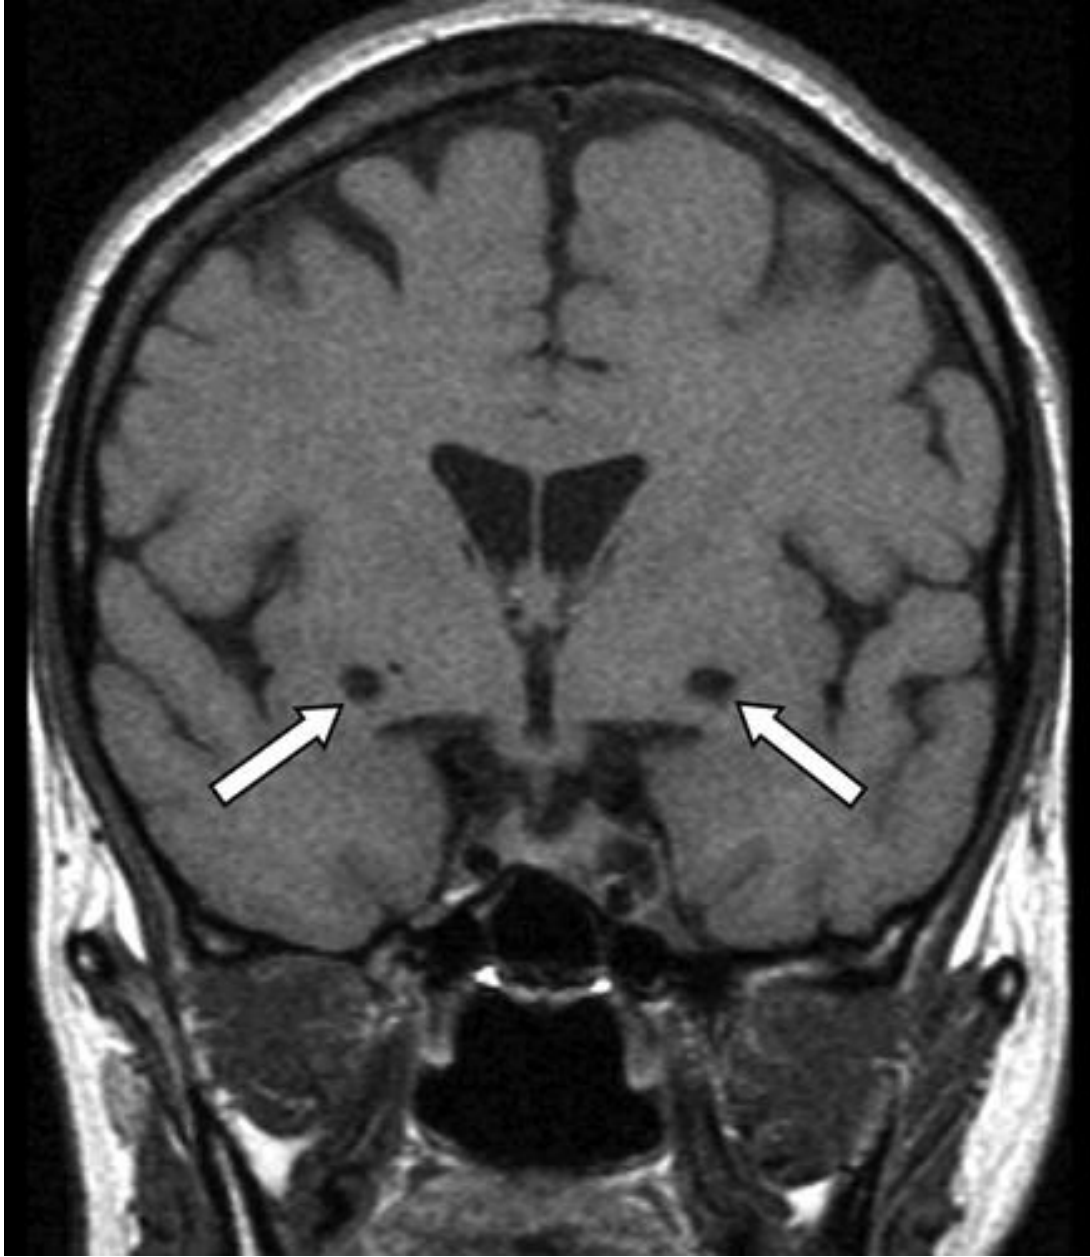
MR image showing Virchow Robin spaces (Qu et al., 2020).
